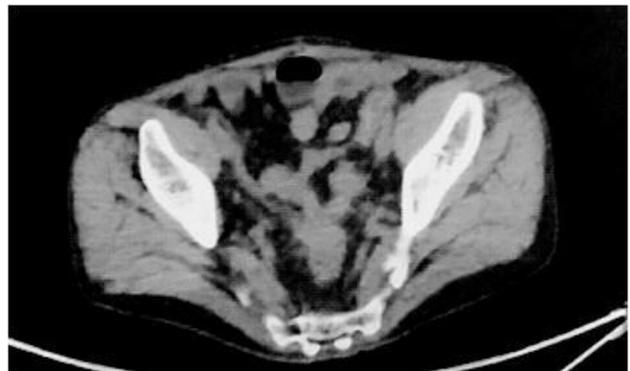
Rectal wall thickening on CT.
